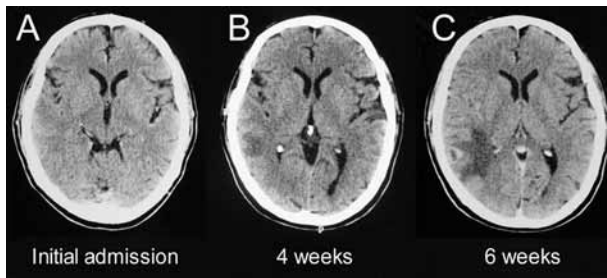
A : Contrast enhanced CT. No unusual findings ; B : 4 weeks later a lesion in the right temporal lobe appeared ; C : follow up CT two weeks later demonstrated the lesion with a thick irregular ring of enhancement.
